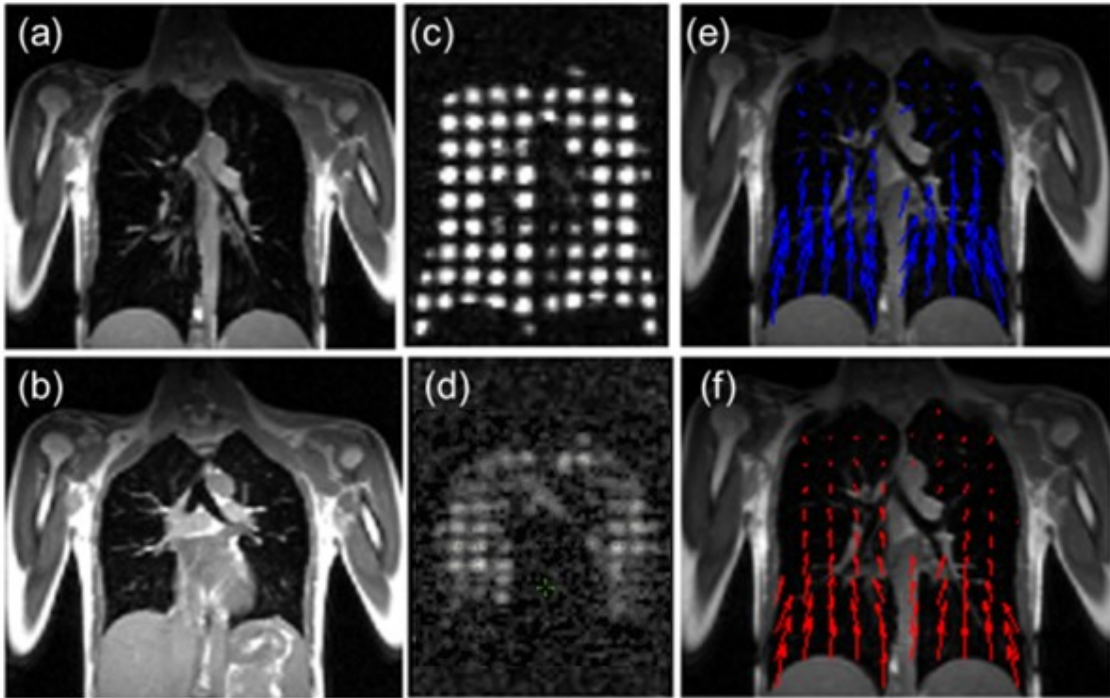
Examples of MR images and DVFs in the coronal view. High-resolution TrueFISP proton MR images at (a) EOI and (b) EOE; HP He-3 tagging MR images at (c) EOI and (d) EOE; and the corresponding (e) tDVF and (f) dDVF (from VEL).
